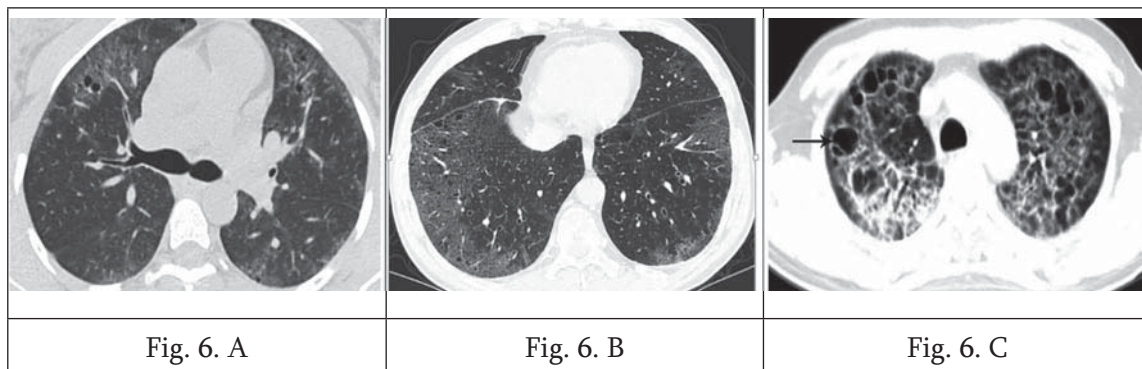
A. Axial computed tomography image from a patient with lymphoid interstitial pneumonia showing thin-walled lung cysts in areas of ground glass opacities. B. Desquamative interstitial pneumonia in a 52-year-old smoker. CT shows GGO with tiny cysts in both lungs, mainly lower peripheral lungs, almost symmetrically distributed. C. Chest CT of a PCP in an AIDS patient. Patchy shadows and multiple cysts are shown in the upper lobes of lungs.
